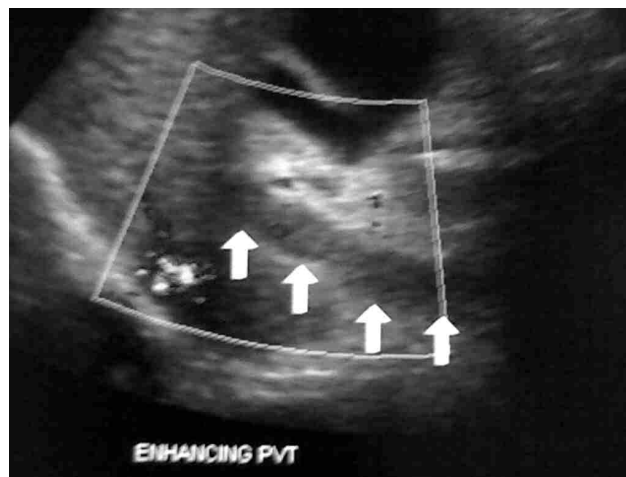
Color doppler sonography of another patient revealed arterial flow in portal vein thrombus (i.e malignant thrombus)
